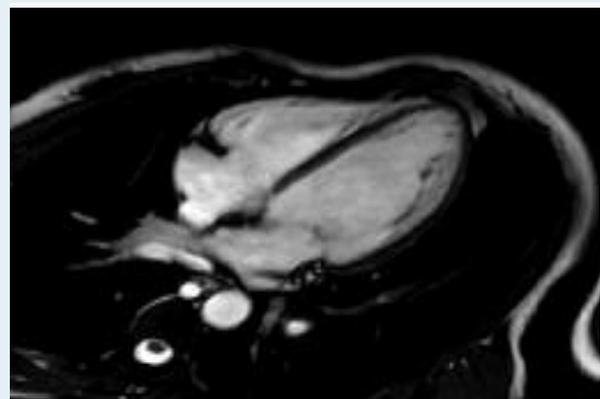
Cardiac magnetic resonance imaging showing an increase in endocardial LV trabeculation interesting the lateral wall with a maximum ratio of non-compacted layer to compacted layer is 3,8
